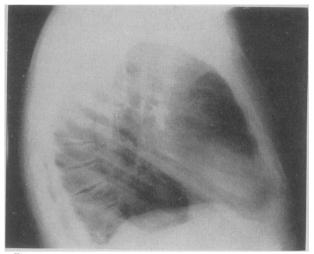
Lateral radiograph of the chest showing the anterior location of this soft tissue shadow.
